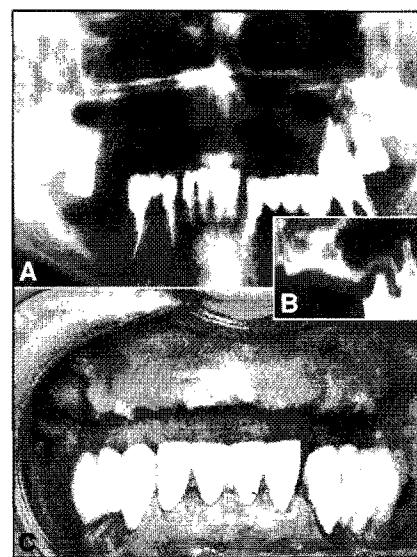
At the patient's first consultation at the end of 2002, she had only 3 remaining posterior teeth in the maxillary (A). They were sources of infection into the sinus and had induced the polypoid thickening visible on the computed tomography scans (B). The patient displayed considerable maxillary bone resorption, which had contributed to the collapse of the lower level of the face and to the absence of lip support. Extraction of the infected teeth and cleansing of the oral cavity revealed extremely thin maxillary alveolar ridges (C).
